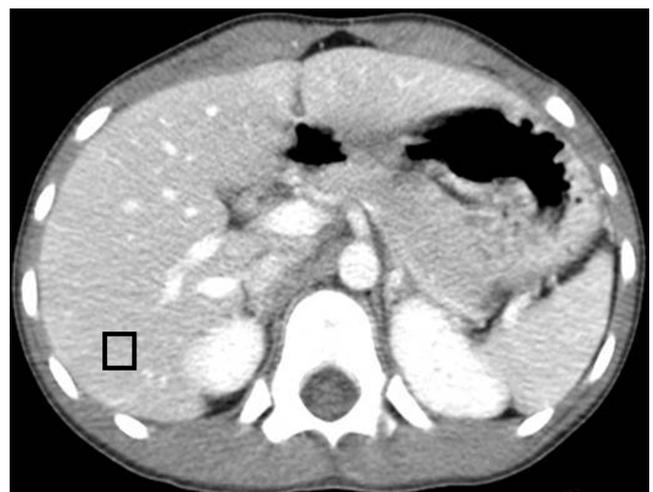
An abdominal CT image at the level of the celiac axis shows a rectangular region of interest in the posterior segment of the right hepatic lobe used for measuring image noise (standard deviation of measured CT density).
